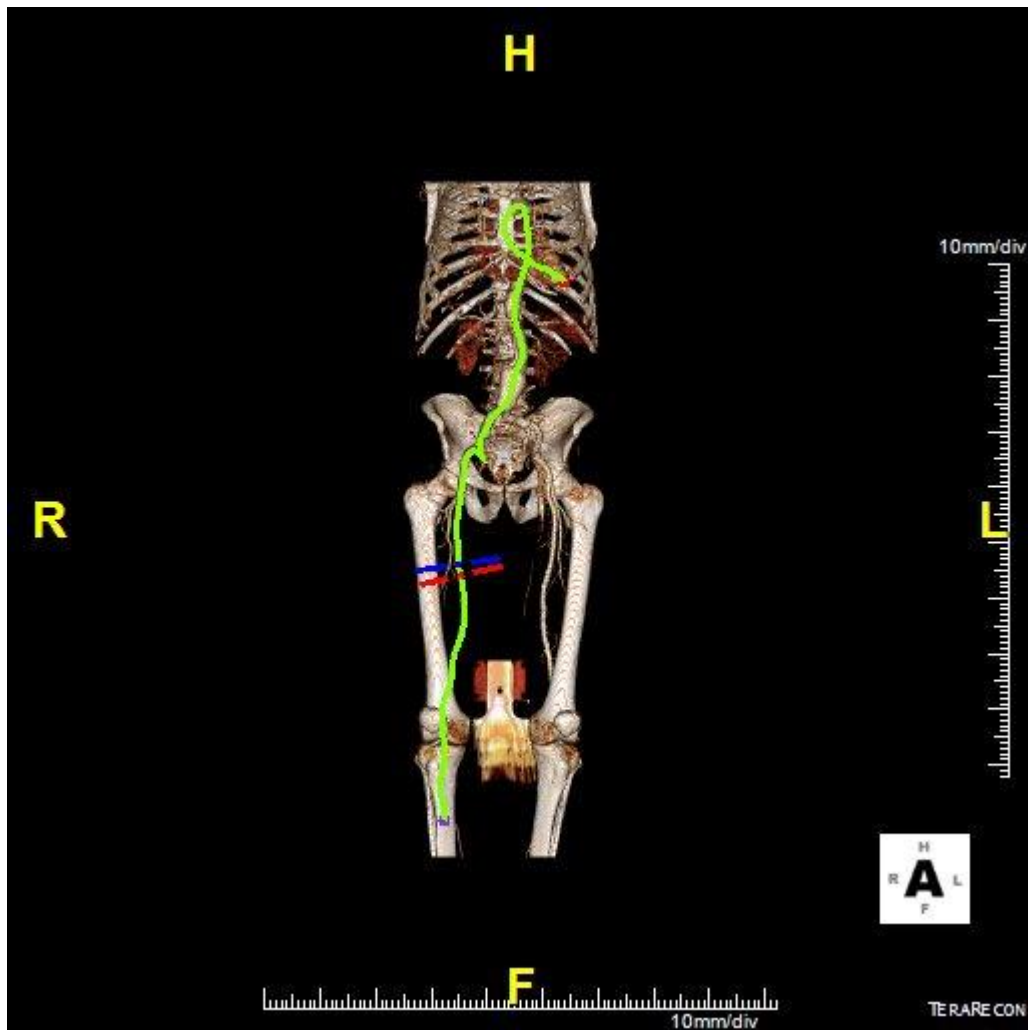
Example case of TeraRecon software used to calculate morphological aneurysm features in patients with available CT angiogram (CTA) imaging.
